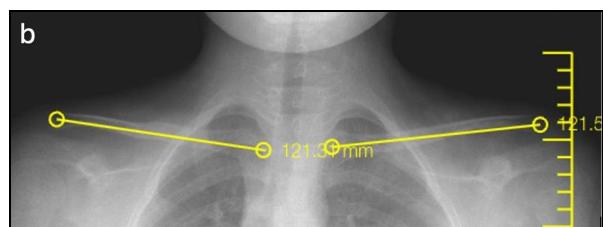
Measurement of shortening on the clavicle anteroposterior radiograph at 1 year.
